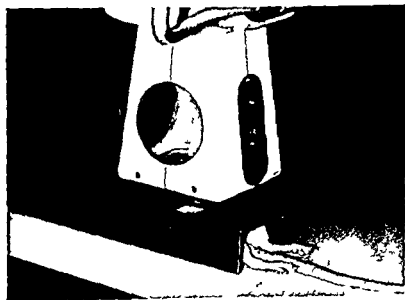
Set up for the roentgen irradiation
